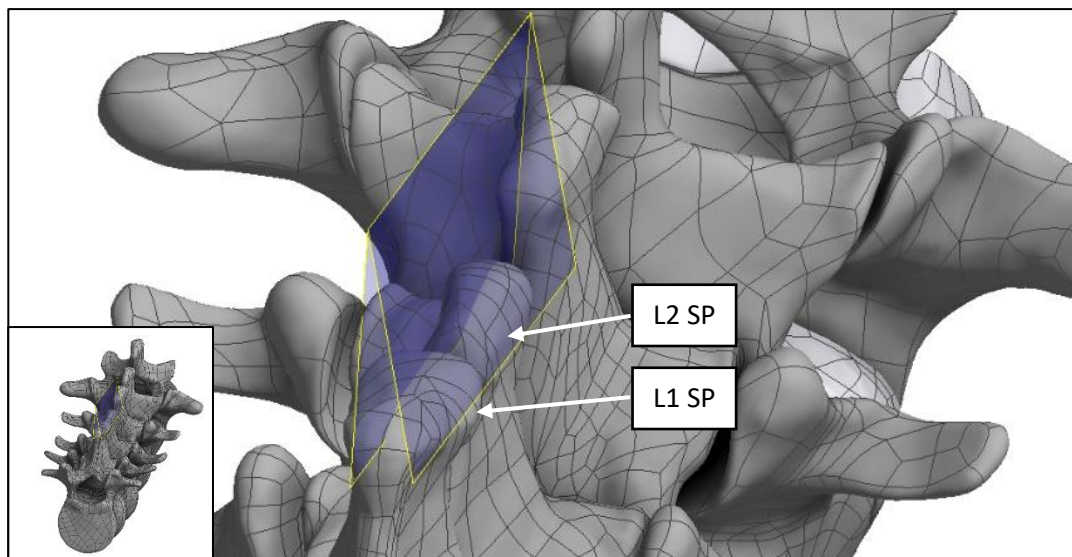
A 3D spine model used to visualize the tilting acquisition window (represented by blue planes). Outside of this window, the ultrasound slice will not intersect the SP and the returning echo will be weak or non-existent. This theoretical acquisition window was investigated experimentally.
